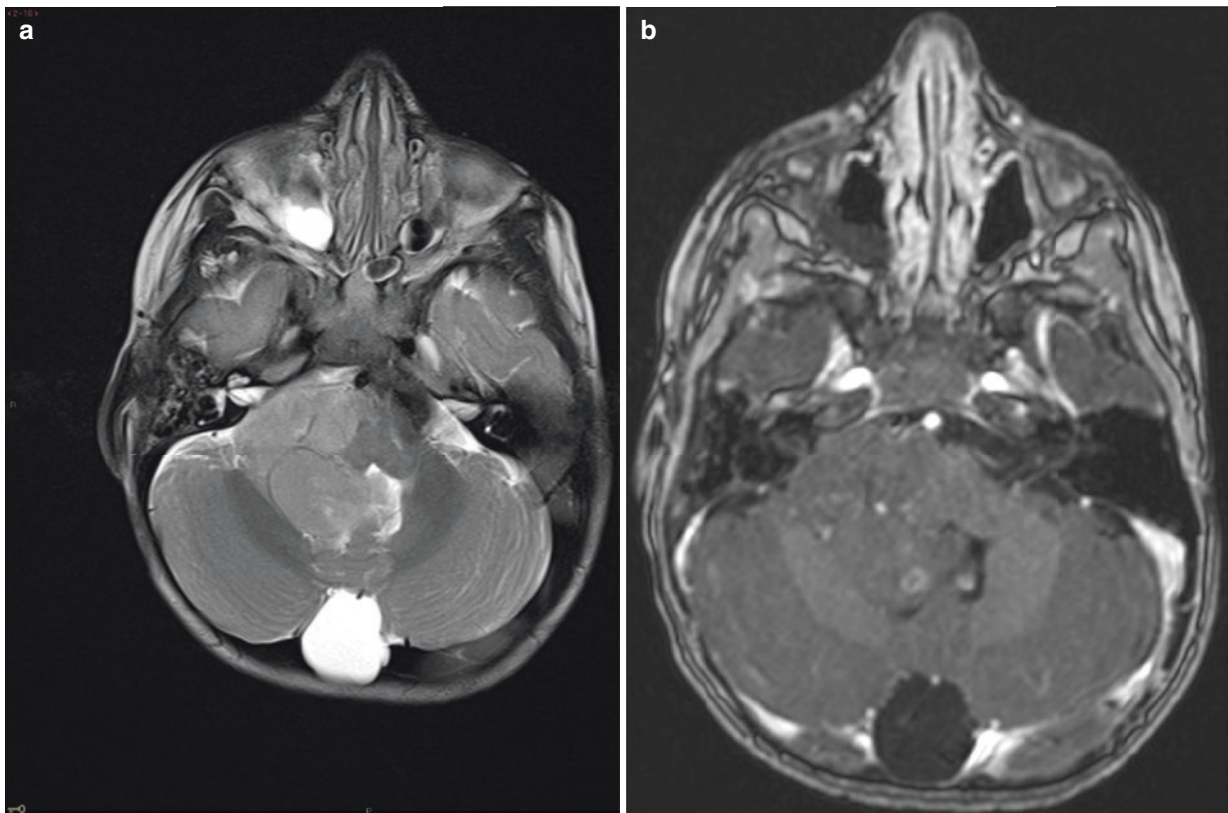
Ependymoma with extension through the foramen of Luschka. (a) Axial T2-weighted MR image shows an isointense mass arising from the fourth ventricle and extending through the right foramen of Luschka to fill the right cerebellopontine angle. (b) Axial post-contrast T1-weighted MR image shows that the mass is poorly enhancing
